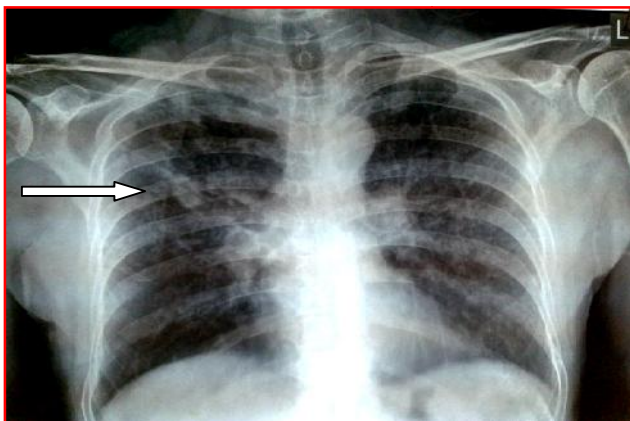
X-ray Chest PA shows b/l hyperinflation and diffuse reticulo nodular pattern with nodular opacity
